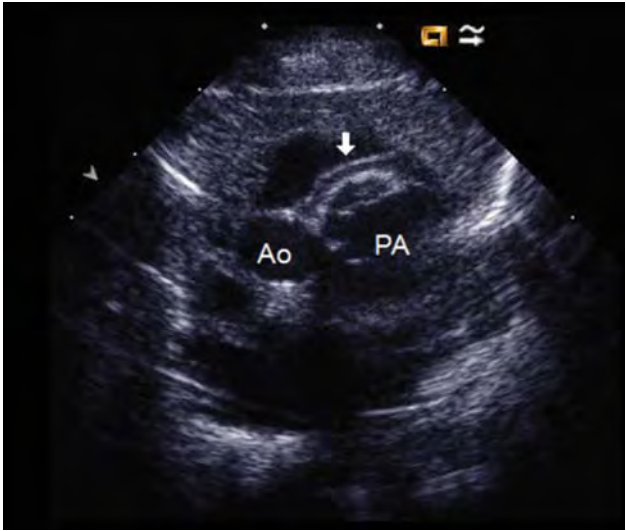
Parasternal short-axis view demonstrating side-by-side great arteries with the left coronary artery crossing the pulmonary outflow tract anteriorly (arrow). Ao, aorta; PA, pulmonary artery.
